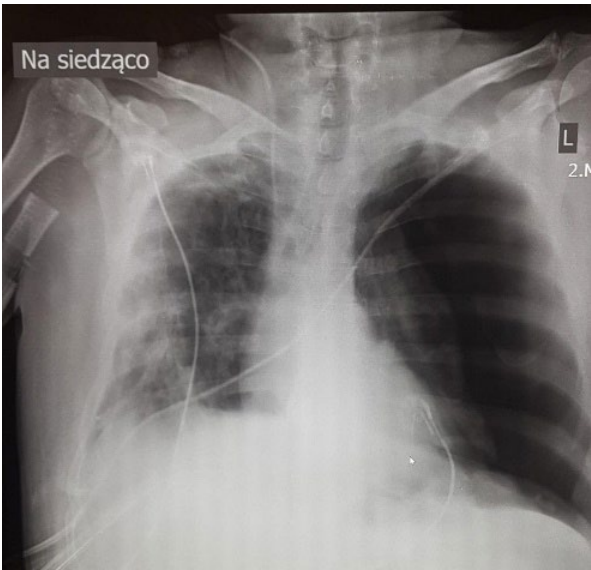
Imaging examinations – chest X-ray from November 28, 2020 – right pleura drainage, abscess on the left side
